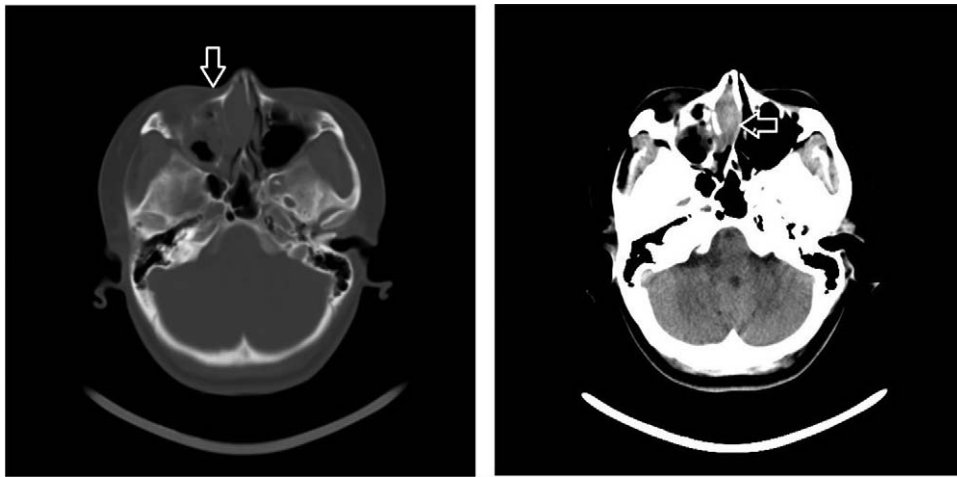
Computed tomography imaging of the tumor. A mass measuring approximately 5 cm × 4 cm was detected in the right frontal lobe and involved the genu of the corpus callosum (arrow). The mass also filled the right nasal cavity (arrow). The nasal septum and ethmoid bone were compressed and bent.
